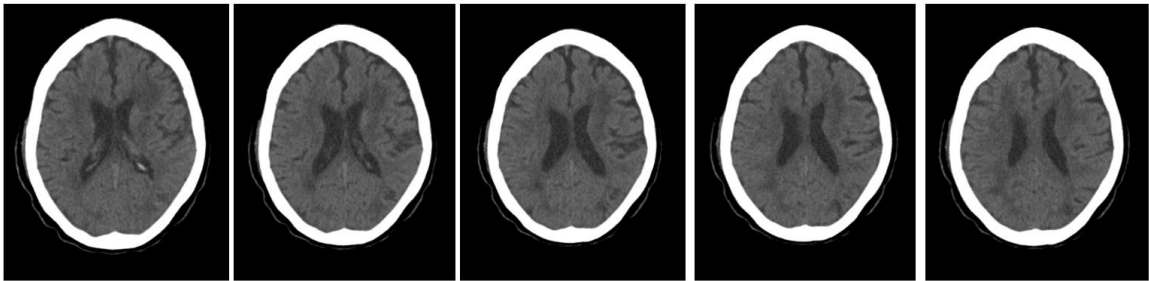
Sequence of slices in the same patient representing the slices selected by the physician. This patient CT scan sequence had a total of 94 slices, and 5 slices were selected.
